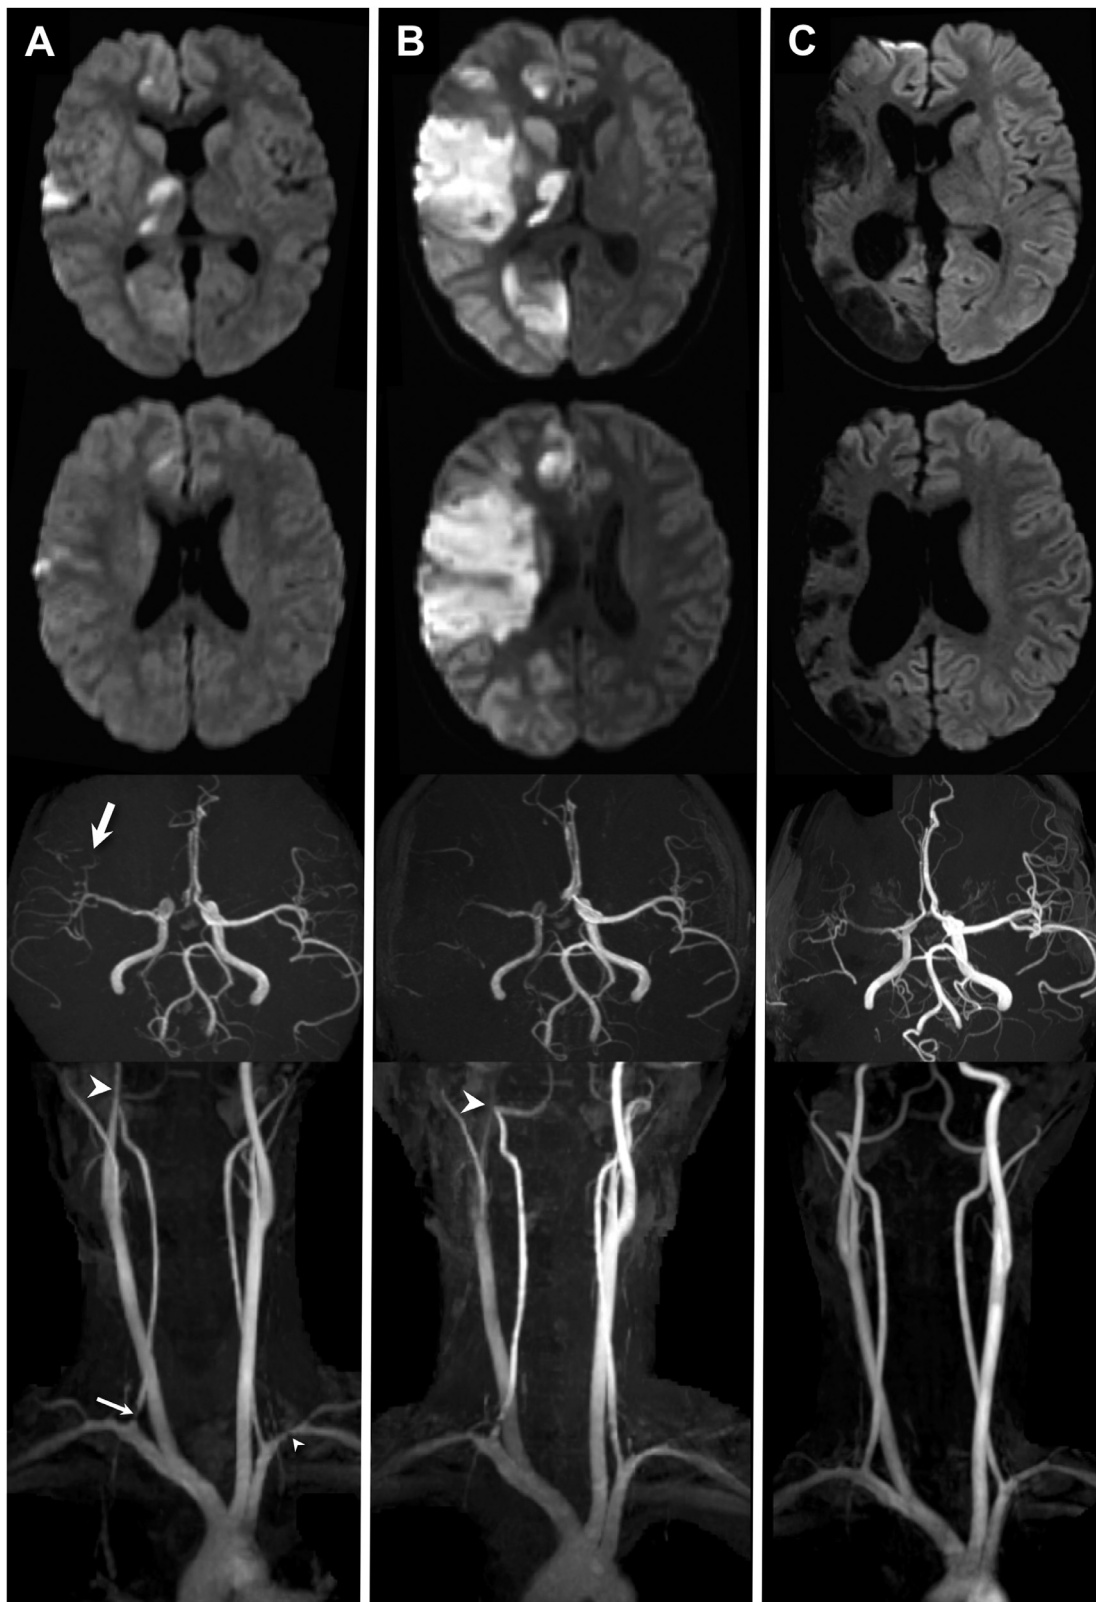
Chronological findings on diffusion-weighted imaging (DWI) (upper) and intracranial/cervical magnetic resonance angiography (MRA) (lower). (A) Upon clinical onset, DWI revealed lesions with a high signal at the right hemisphere. MRA showed multiple stenosis in the right middle cerebral artery (MCA) (thick white arrow)/cervical internal carotid artery (ICA) (thick white arrowhead)/vertebral artery origin (thin white arrow) and the left subclavian artery (thin white arrowhead). (B) Six days after onset, DWI showed progressive cerebral infarction at the right hemisphere. MRA revealed progressive severe stenosis in the right MCA and the cervical ICA (thick white arrowhead). (C) Follow-up magnetic resonance imaging showed a massive old cerebral infarction at the right hemisphere. MRA revealed improvement in multiple intracranial and extracranial artery stenosis.
